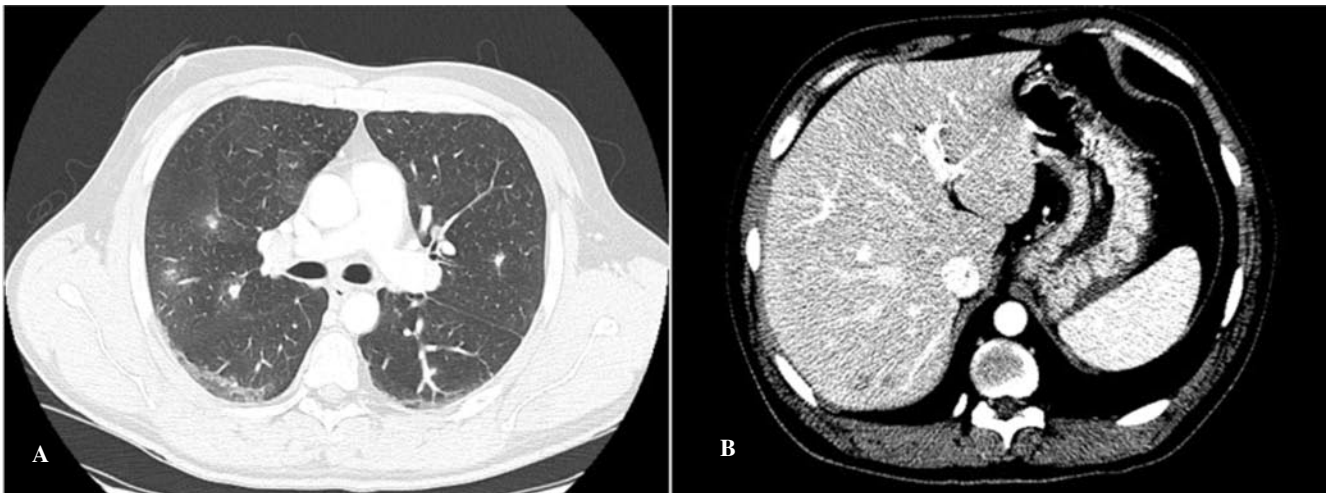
Contrast enhanced CT scan of the chest and abdomen.
